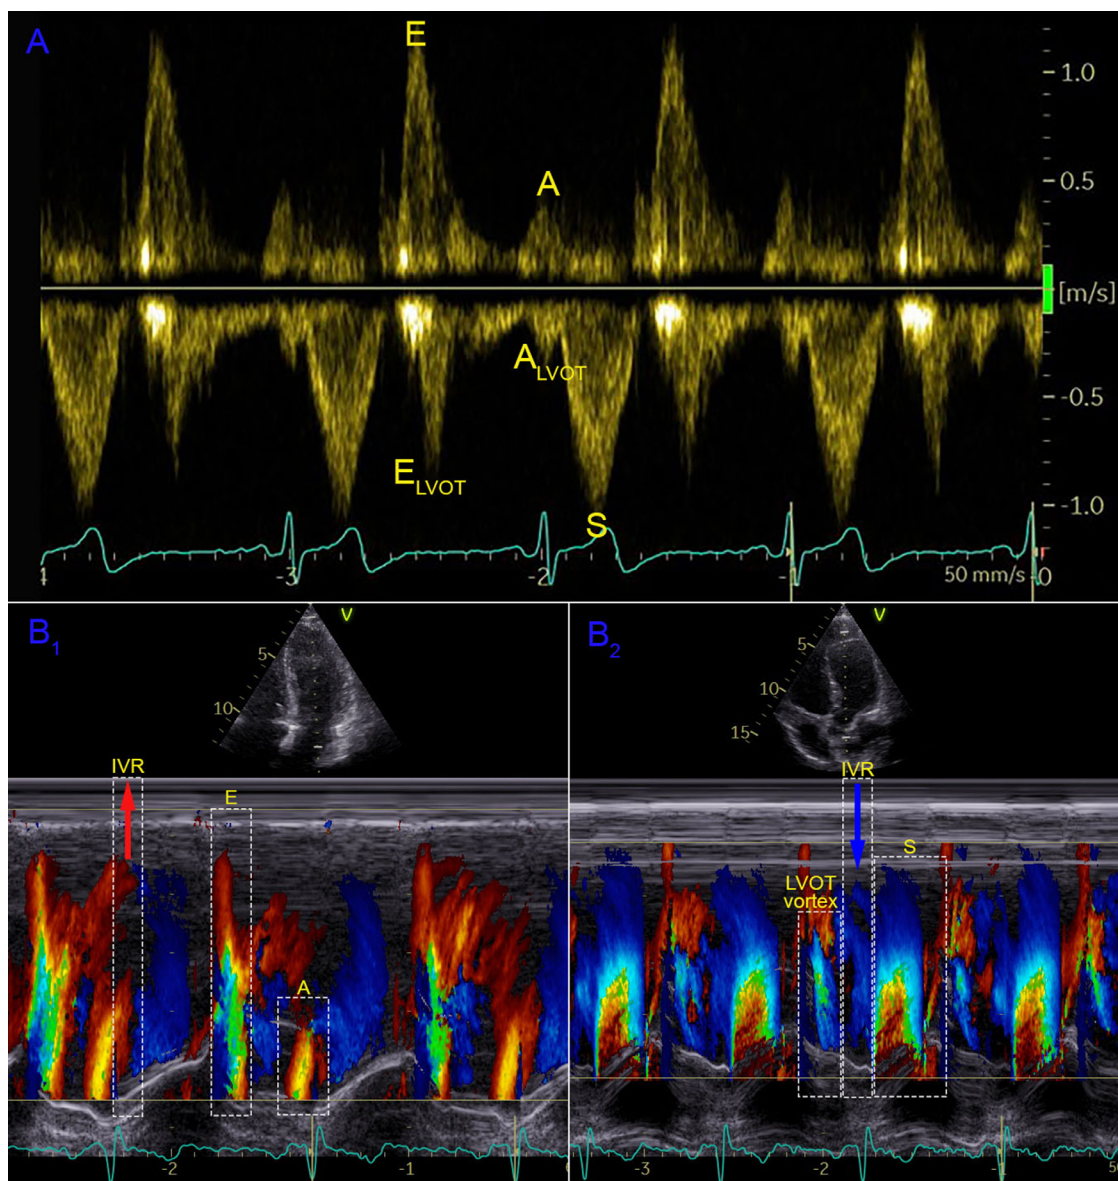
Intraventricular vortices and flow visualized. (a) Pulsed-wave (PW) Doppler trace with sample volume between the mitral and aortic valve visualizing the E-wave, the A-wave and the delayed mirrored E-wave and A-wave in the opposite direction in the left ventricular outflow tract (LVOT). We also see the ejection (the S-wave). Apically directed flow can also be seen during IVR. (b) Color M-mode (CMM) recordings through the mitral valve and the LVOT, respectively. B₁: E-wave and A-wave and IVR-flow, all directed toward the apex. B₂: Shows the vortex in the LVOT, the S wave with direction toward the base and IVR-flow directed toward the apex.
